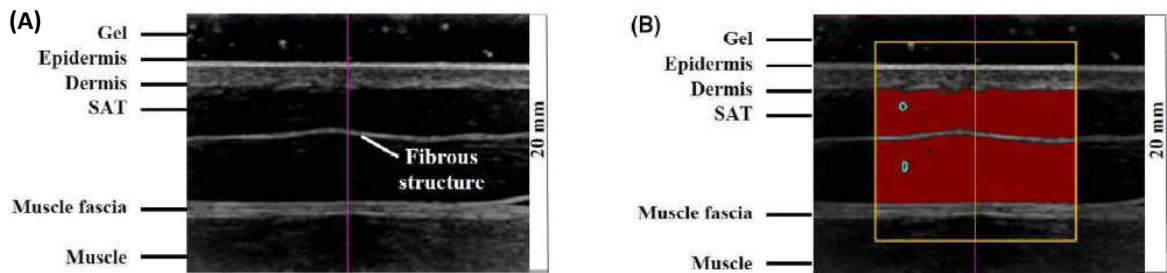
“A, Typical example of an ultrasound image (US) of subcutaneous adipose tissue (SAT). Site: front thigh (FT). Tissue structures of relevance for US image evaluation are marked. B, The semi-automatic SAT detection algorithm starts out from the blue zones. The yellow frame represents the chosen region of interest. The evaluation algorithm measured automatically 235 SAT thicknesses of the SAT layer along 235 vertical lines in this image. Mean  $d_I = 8.10 (\pm 0.11) \text{ mm}$ ,  $d_E = 7.61 (\pm 0.12) \text{ mm}$ , and the difference  $d_F = 0.49 \text{ mm}$  (represents the mean thickness of the embedded fibrous structure). Image depth was 20 mm” (58). Reproduced from “Body weight and subcutaneous fat patterning in elite judokas, Sengeis M., Müller W., Störchle P. et al., Scand J Med Sci Sports 2019;00:1–15; with permission from John Wiley & Sons, Inc.
